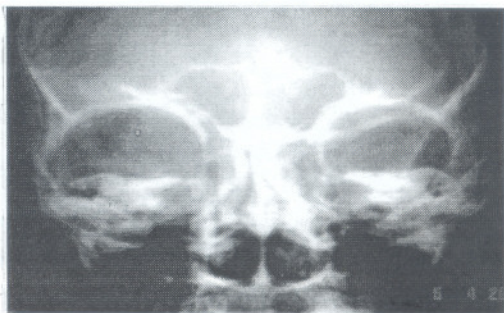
Plain x-ray skull P/A view-showing right orbit is enlarged with destruction of lesser and greater wing of sphenoid bone at right side.
